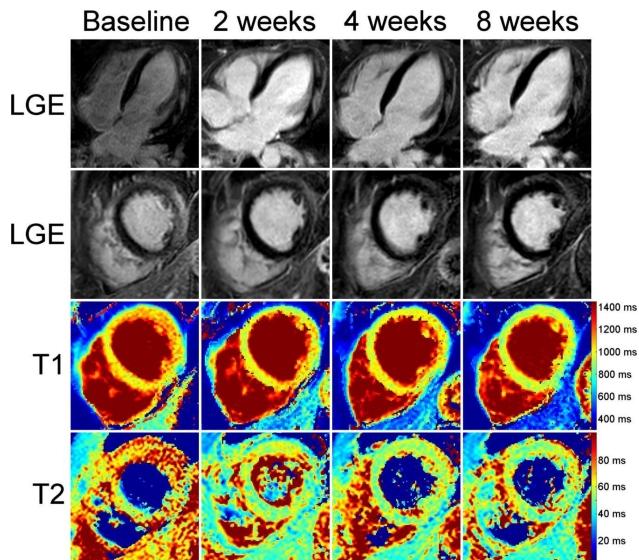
Cardiac magnetic resonance imaging with T1 and T2-weighted imaging and late gadolinium enhancement (LGE) showing myocardial edema and patchy enhancement, characteristic of myocarditis [19].
